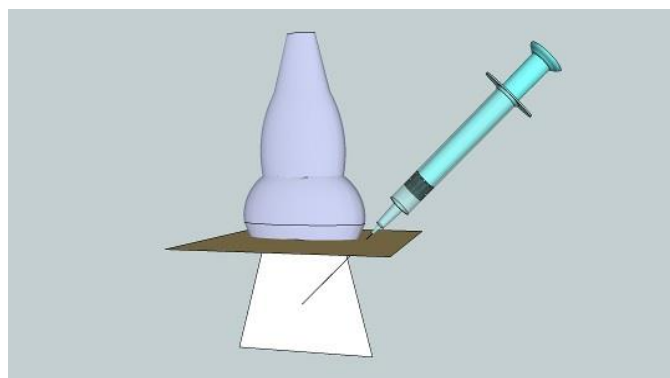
Inplane approach of ultrasonography
